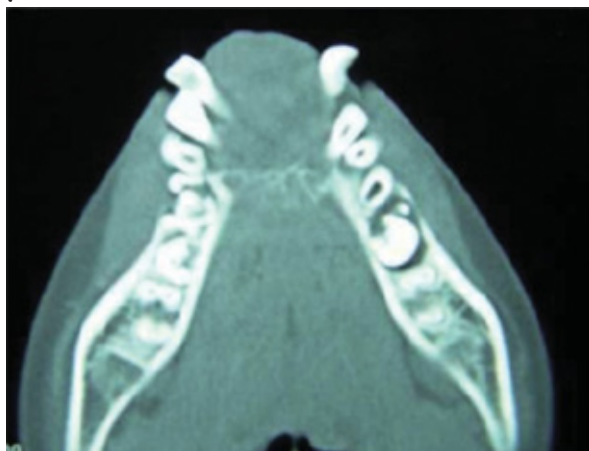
Axial computed tomography showing expansion of cortices with central radiopacities
